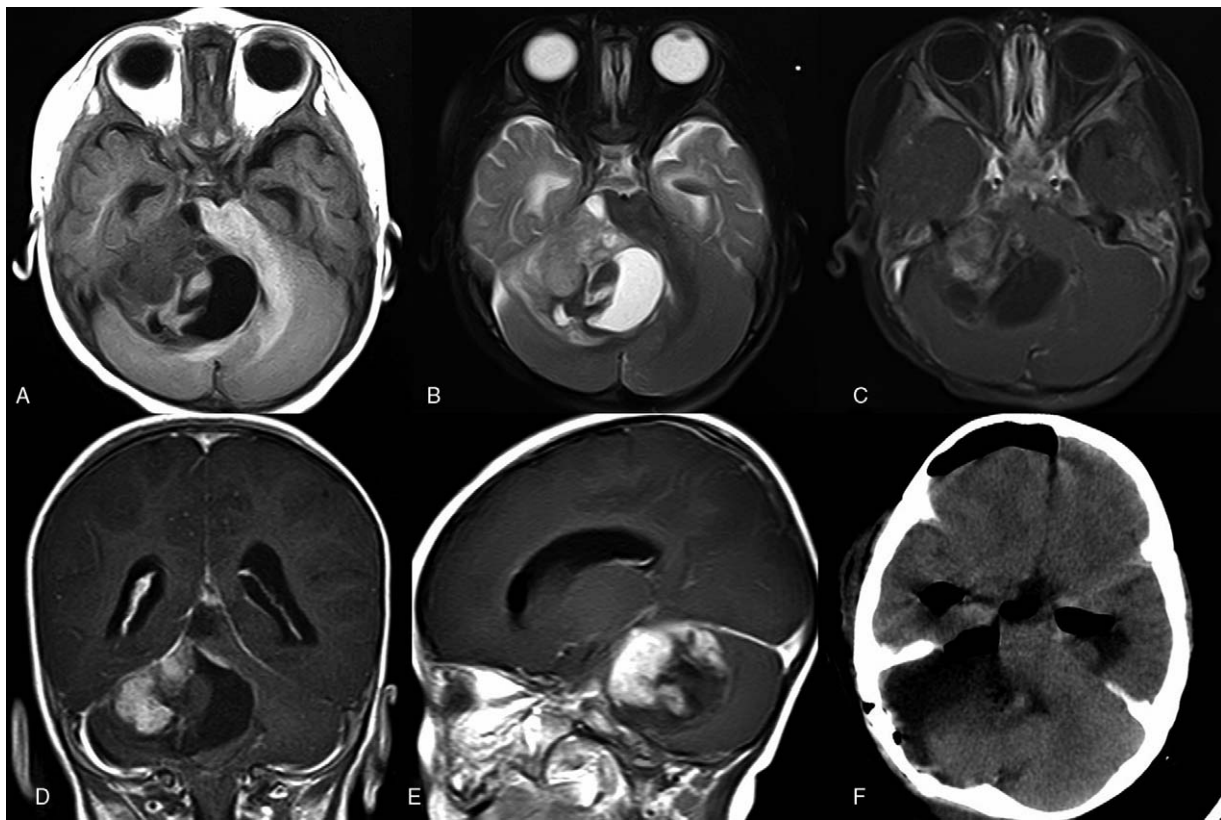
Images for patient 2. (A) Preoperative T1-weighted magnetic resonance imaging (MRI) showing the mass in the right cerebellopontine angle. (B) Preoperative T2-weighted MRI showing cystic changes of the tumor. (C) Postcontrast T1-weighted MRI showing heterogeneous enhancement in solid part of the tumor. (D) Coronal section of the tumor. (E) sagittal section of the tumor. (F) Postoperative computed tomography (CT) of the patient showing complete resection of lesion and relief of supratentorial pressure. CT=computed tomography.
